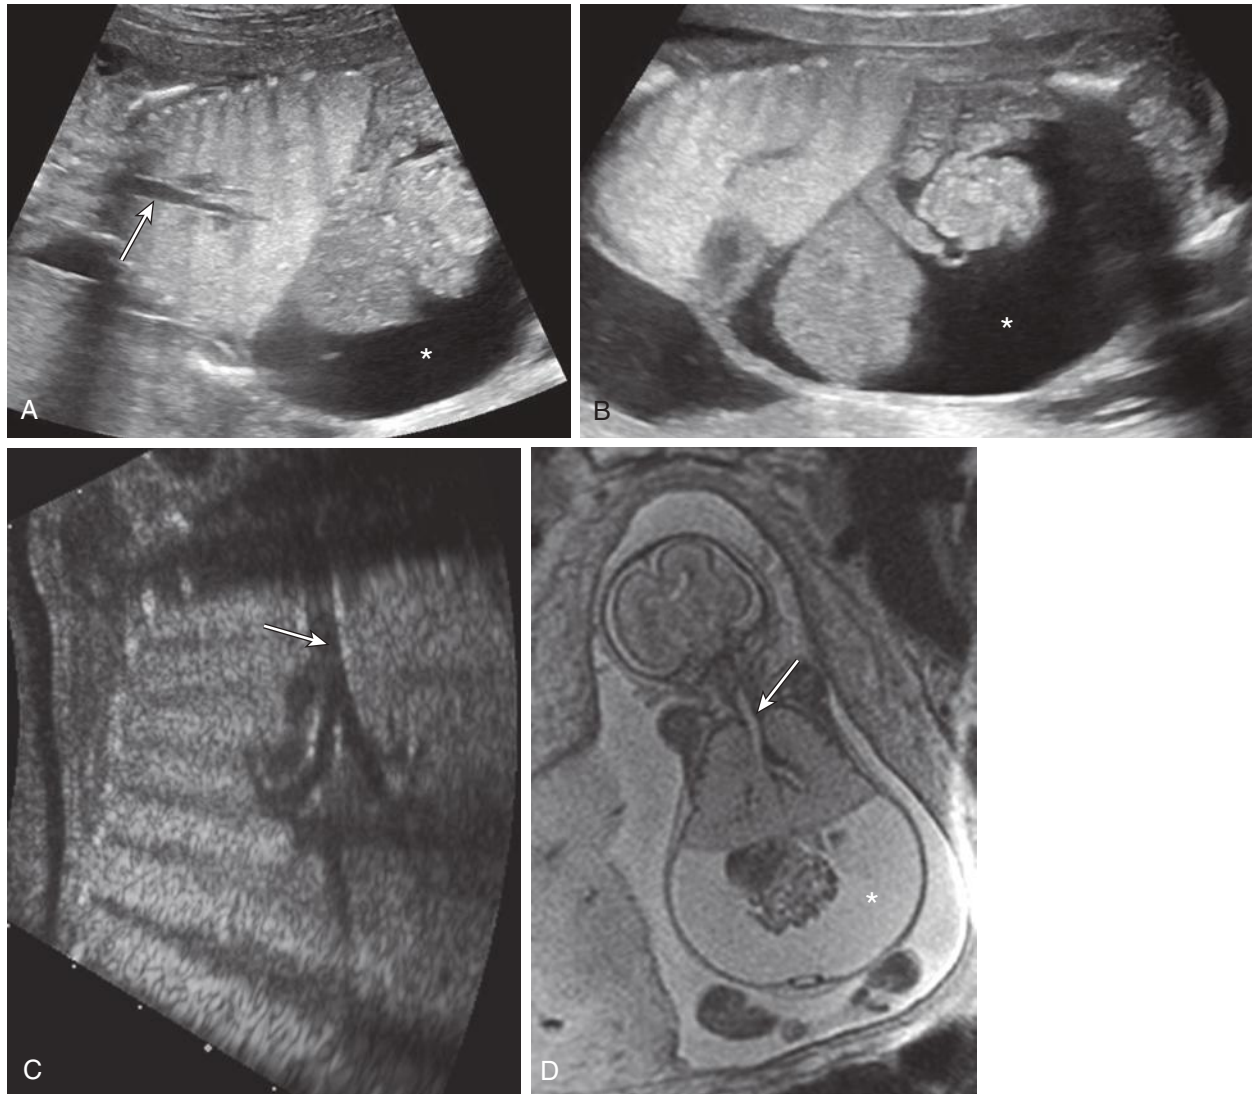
Congenital high airway obstruction syndrome (CHAOS). Coronal (A and C) and sagittal (B) images demonstrate dilated fluid-filled trachea (*arrow*), enlarged hyperechoic bilateral lungs, and hydrops with ascites (*asterisk*). D, Coronal magnetic resonance image demonstrates the same findings of a dilated trachea (*arrow*) and ascites (*asterisk*).
